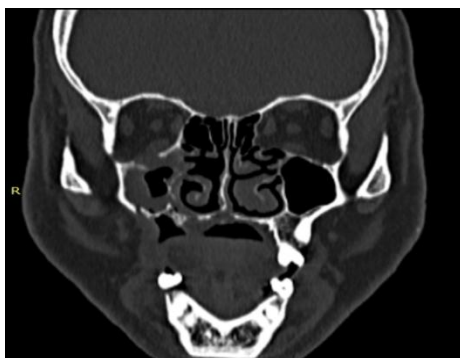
CT face revealing de-ossification and erosive changes at the right maxillary alveolus, medial and postero-lateral walls of the right maxillary sinus.
